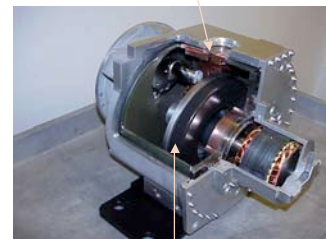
Cross-section through a rotating anode x-ray tube
